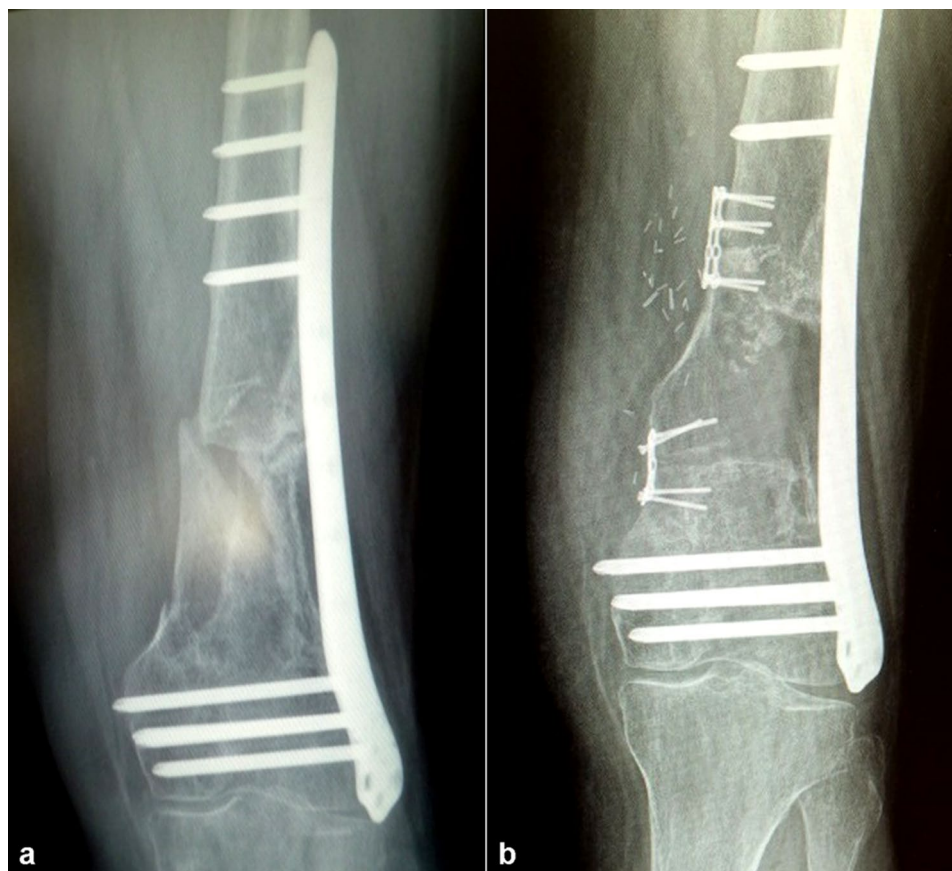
A 53-years-old female patient with a distal diaphyseal femoral fracture. X-rays before (a) and after (b). (a) non-union before reconstruction; (b) result after 3 months (after the reconstruction by MFCF)
